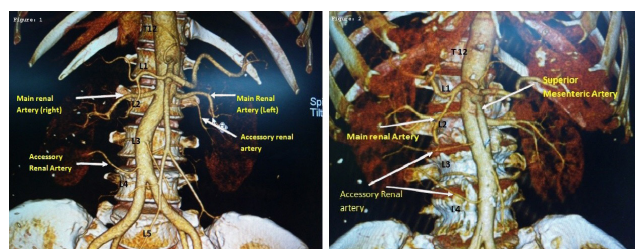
CT angiogram showing the presence of double renal artery on both sides Figure 2. CT angiogram showing the presence of triple renal artery in right side
